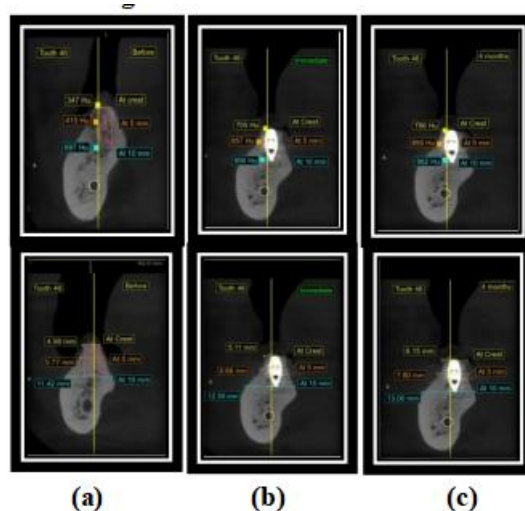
CBCT evaluation of a posterior mandibular implant site treated with osseodensification. (a) Preoperative CBCT image demonstrating baseline ridge width and bone density at the implant site. (b) Immediate postoperative CBCT image showing implant placement and ridge expansion achieved using osseodensification. (c) Four-month postoperative
